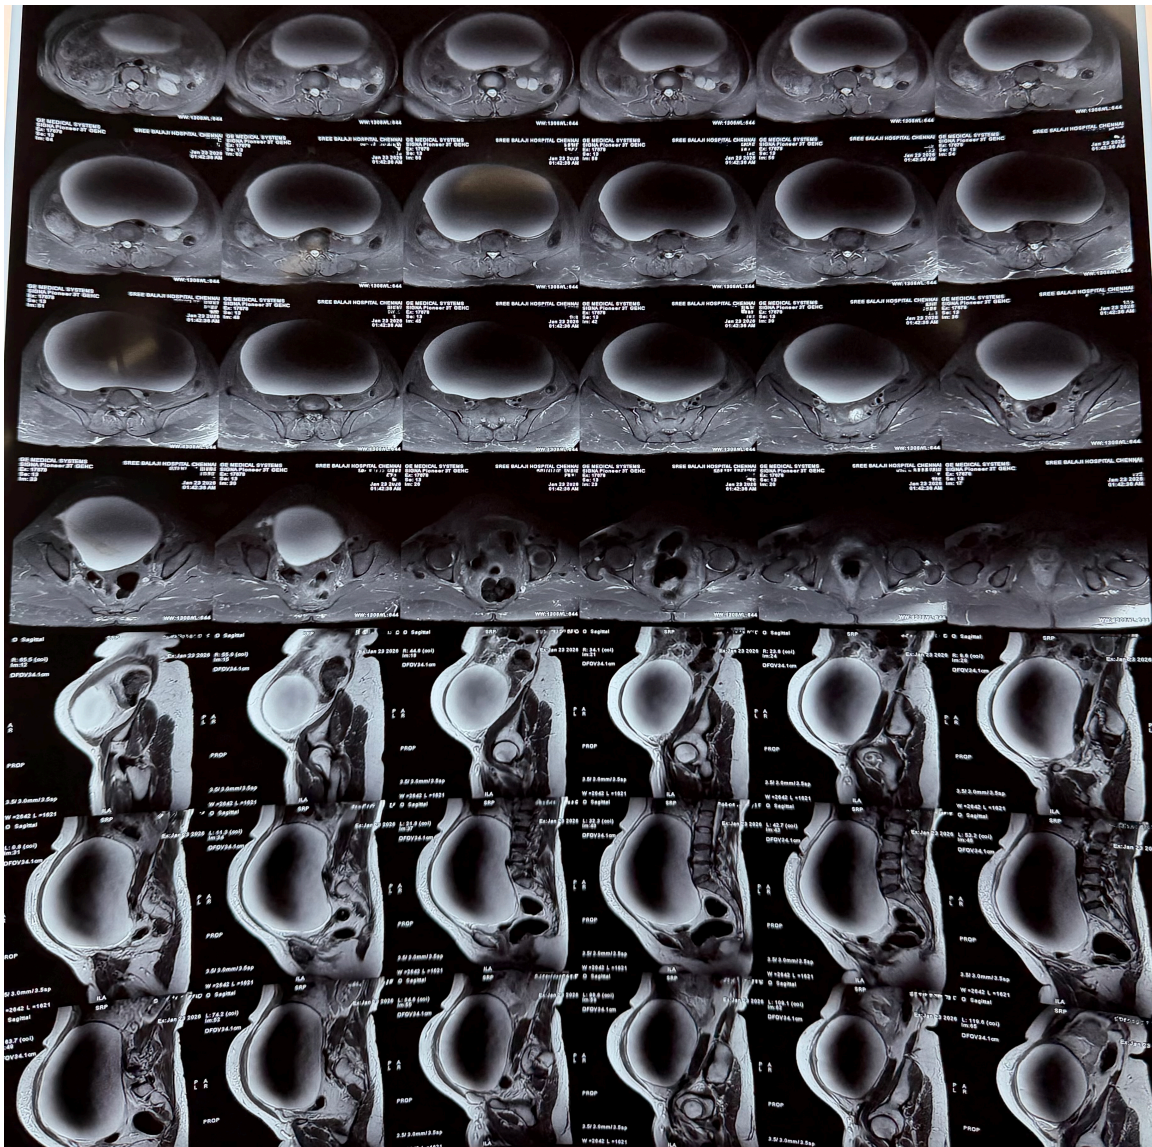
MRI Abdomen and Pelvis
